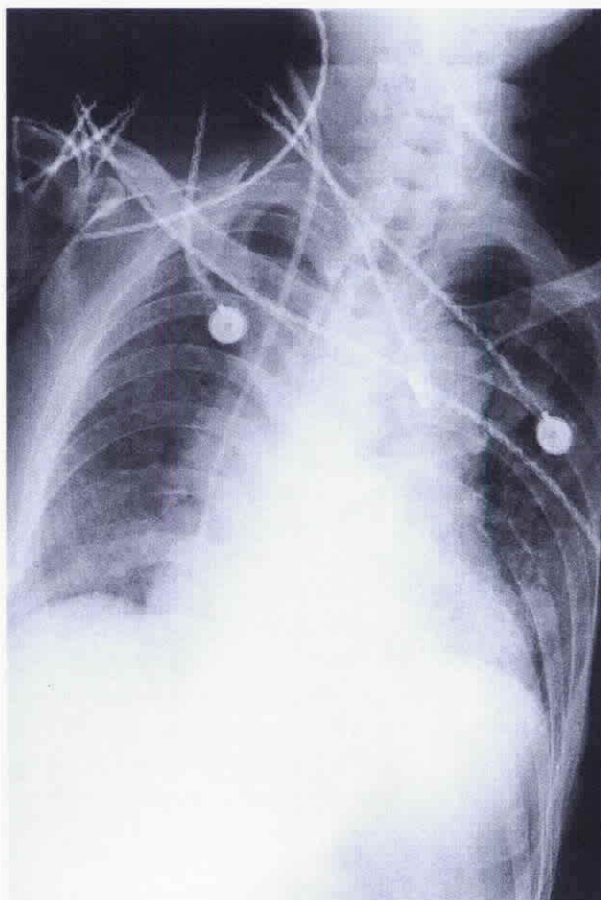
Chest roentgenography revealed bilateral interstitial and alveolar infiltrates on admission.
